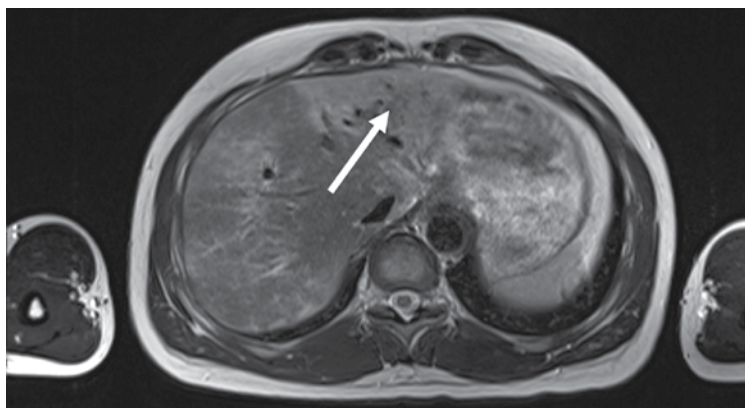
MRI scan of the liver showing fibrotic changes within the left lobe.
